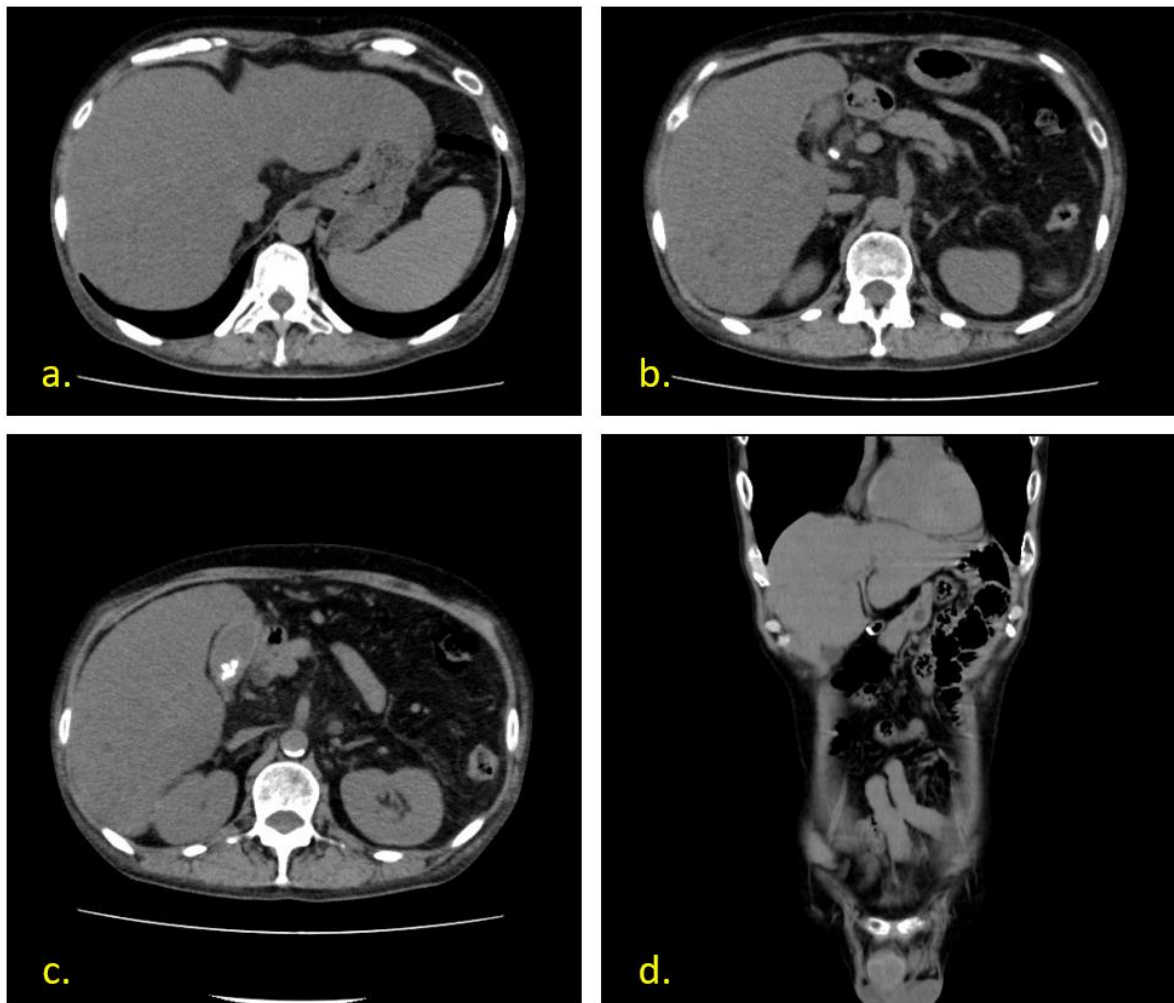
Findings of Abdominal CT Scan
